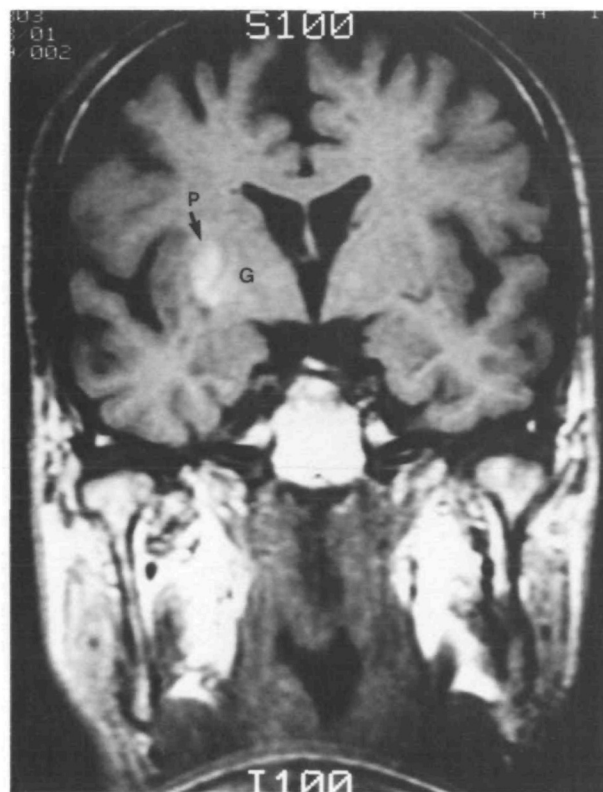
T1-weighted coronal magnetic resonance imaging scan through the basal ganglia 3 weeks after the acute event.
